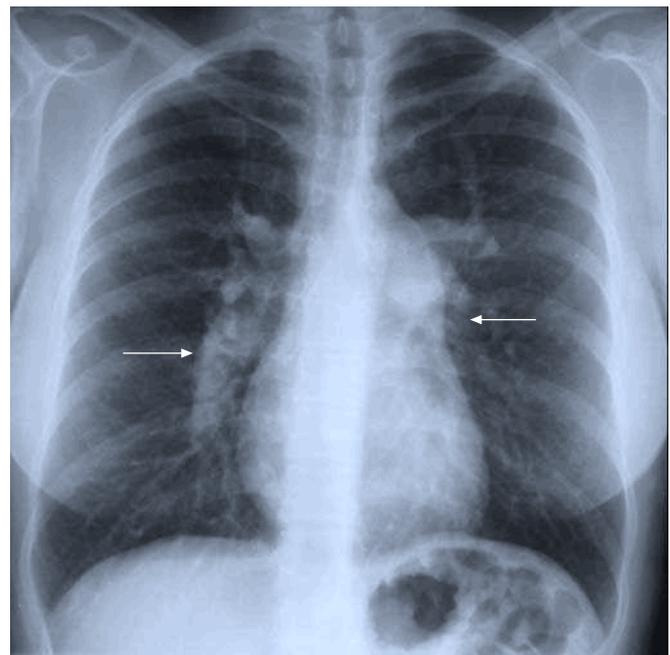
Chest radiograph showing markedly dilated pulmonary arteries (arrows).
